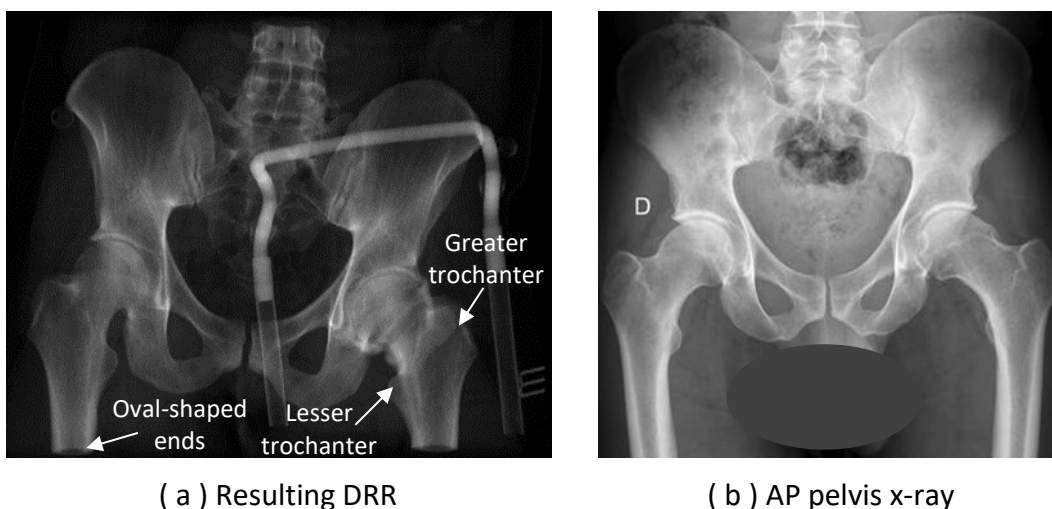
Resulting DRR compared to a clinical x-ray. X-ray image obtained with permission from Valera *et al.* (2016)
